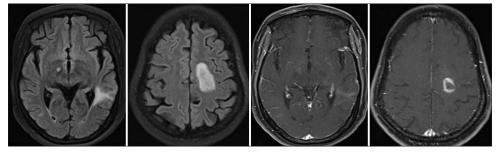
Follow-up MRI shows moderate decrease in size of lesions; however, the lesion in the left centrum semi-ovale appears conspicuous with open ring enhancement
